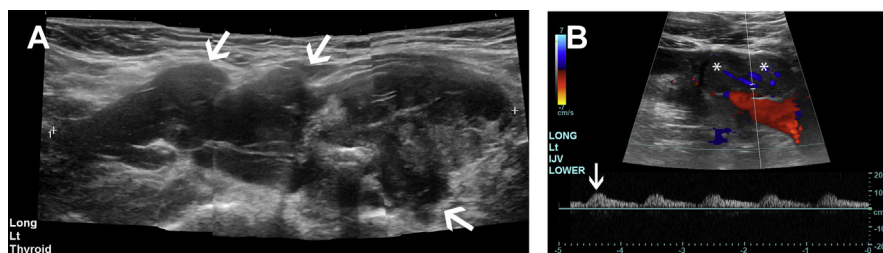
A 59-year-old woman with metastatic follicular carcinoma with Hurthle cell features. (A) Longitudinal gray-scale extended view image shows a large (11 cm) hypoechoic left thyroid mass (*calipers*) with irregular margins and extrathyroidal extension (*arrows*). (B) Longitudinal spectral Doppler of the left lower internal jugular vein demonstrates an intraluminal hypoechoic solid mass (*asterisk*) with arterial flow (*arrow*) indicating tumor invasion into the left internal jugular vein.
